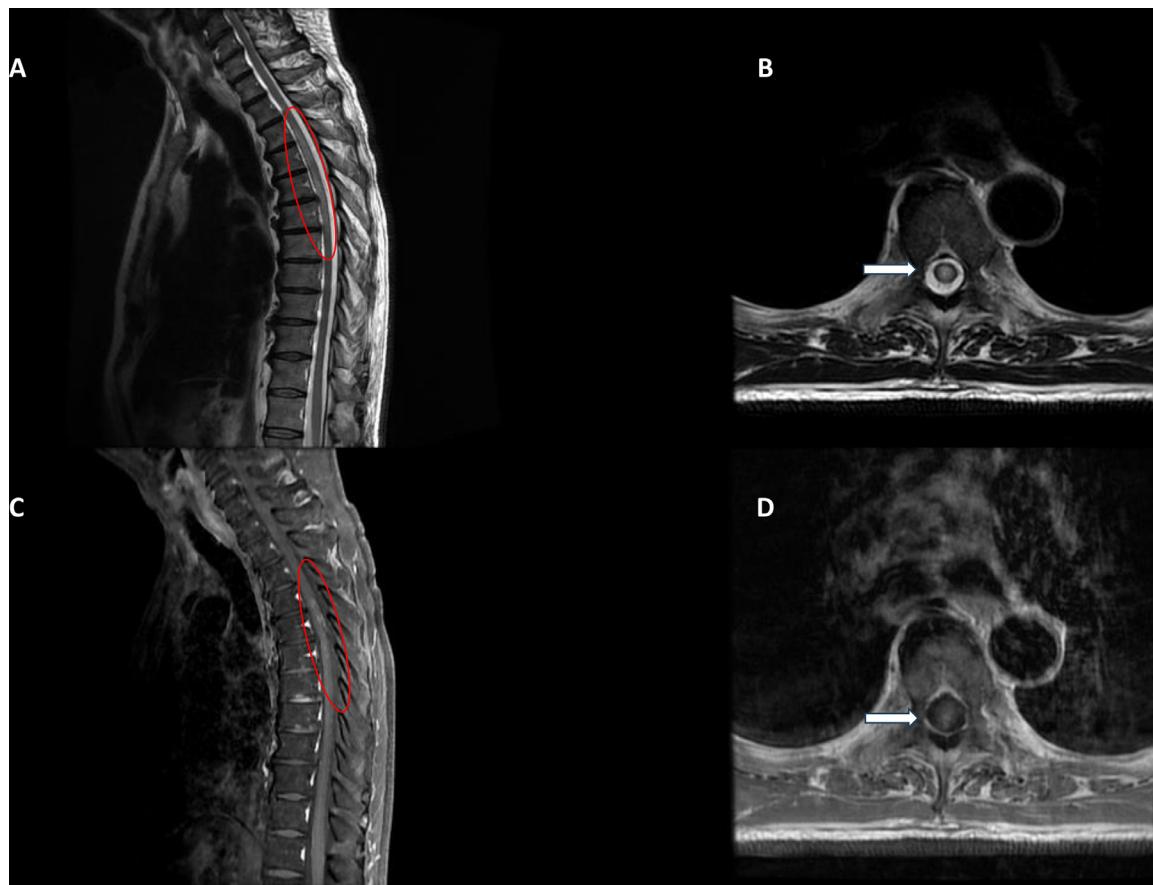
Hyperintense lesions in the thoracic spinal cord from the Th4 to Th8 levels (red circle) (A, B). Contrast enhancement was observed within these lesions (arrow) on post-contrast T1-weighted imaging (T1-WI) (C, D).
